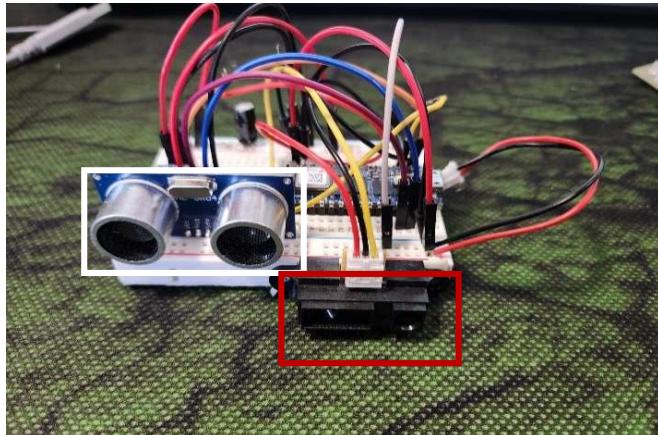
Arduino for Smart Cup with Ultrasonic sensor enclosed in white and IR proximity sensor Enclosed in red.
